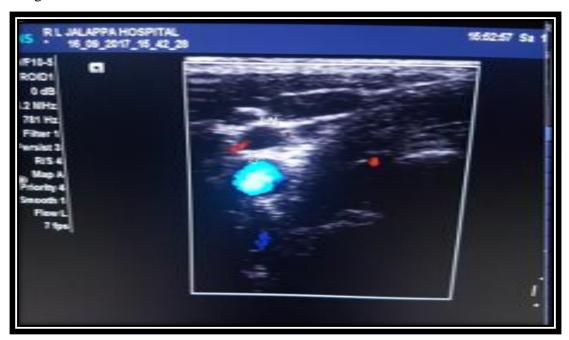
Ultrasound of metastatic lymph node showing increased vascularity
